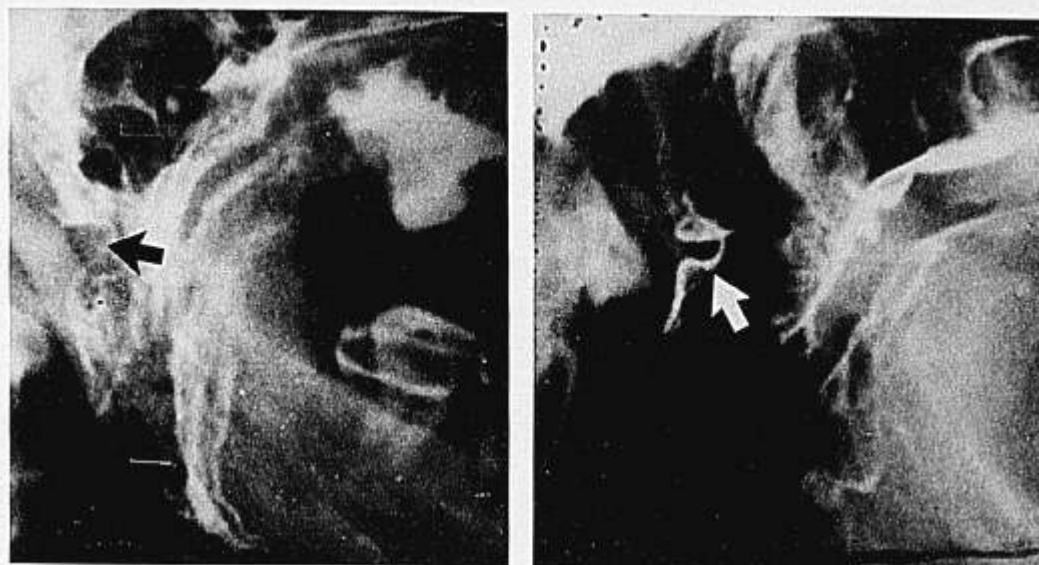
Lateral radiographic view of the velopharyngeal valve during FST in a patient with pharyngeal flap (left) and following excision of carcinoma (right). The arrows indicate Passavant's ridge.
